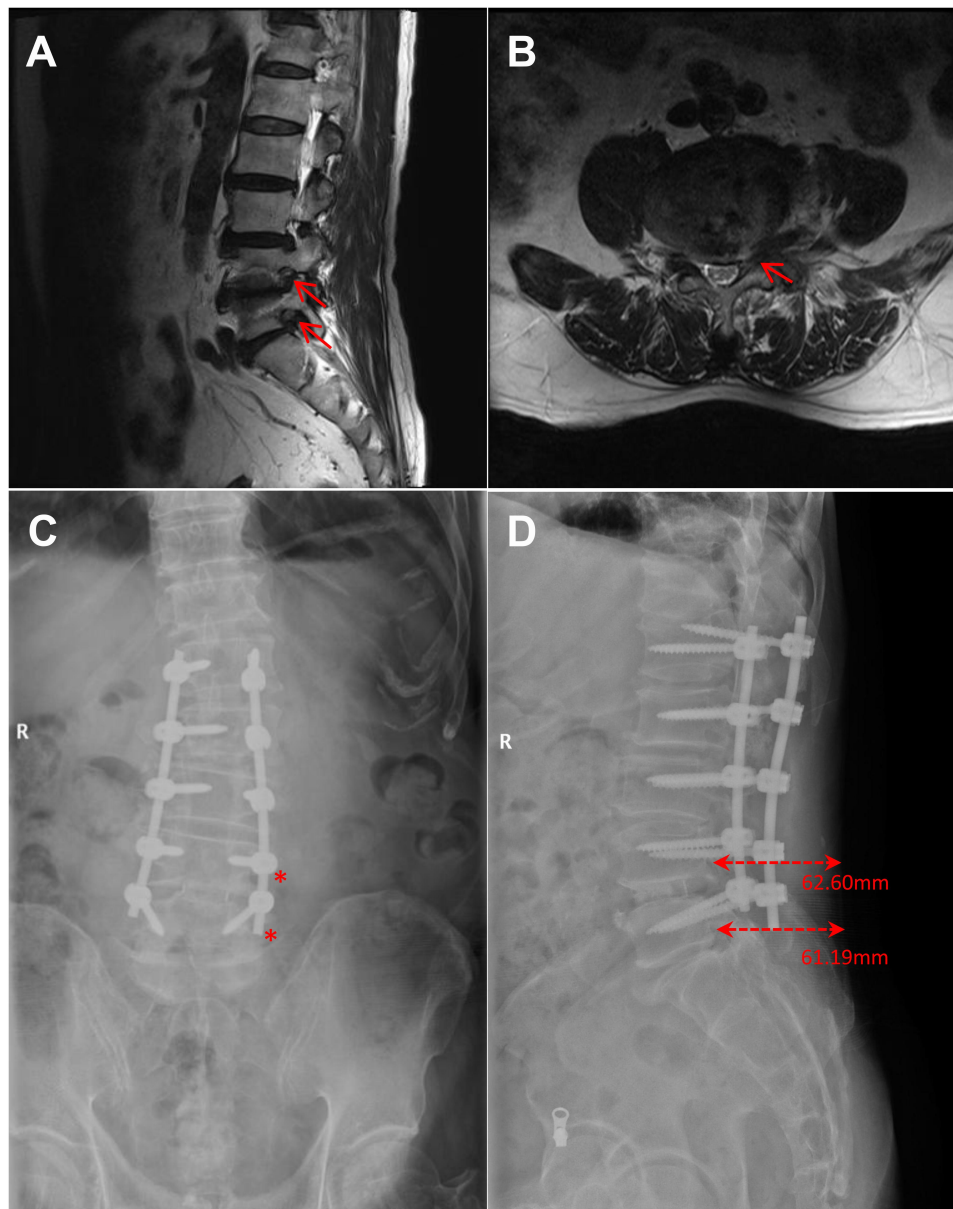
Radiographs. (A) Sagittal plane of the lumbar MR image showed stenosis of the L4-5, L5-S1 left intervertebral foramen (red arrows). (B) Axial plane of the lumbar MR image showed that the herniated disc of L4-5 compressed the nerve root. (C) Anteroposterior lumbar radiograph after surgery. The L4 paravertebral space was just lateral inferior to the last-but-one pedicle screw. The target of the L5 paravertebral space was just in the lateral rod terminal. (D) Lateral lumbar radiograph after surgery. The last-but-one pedicle screw and the terminal of the rod were just next to the needle paths we designed for L4 or L5 PVB. The depth of the needle from the skin to the target was measured, according to the scale.
